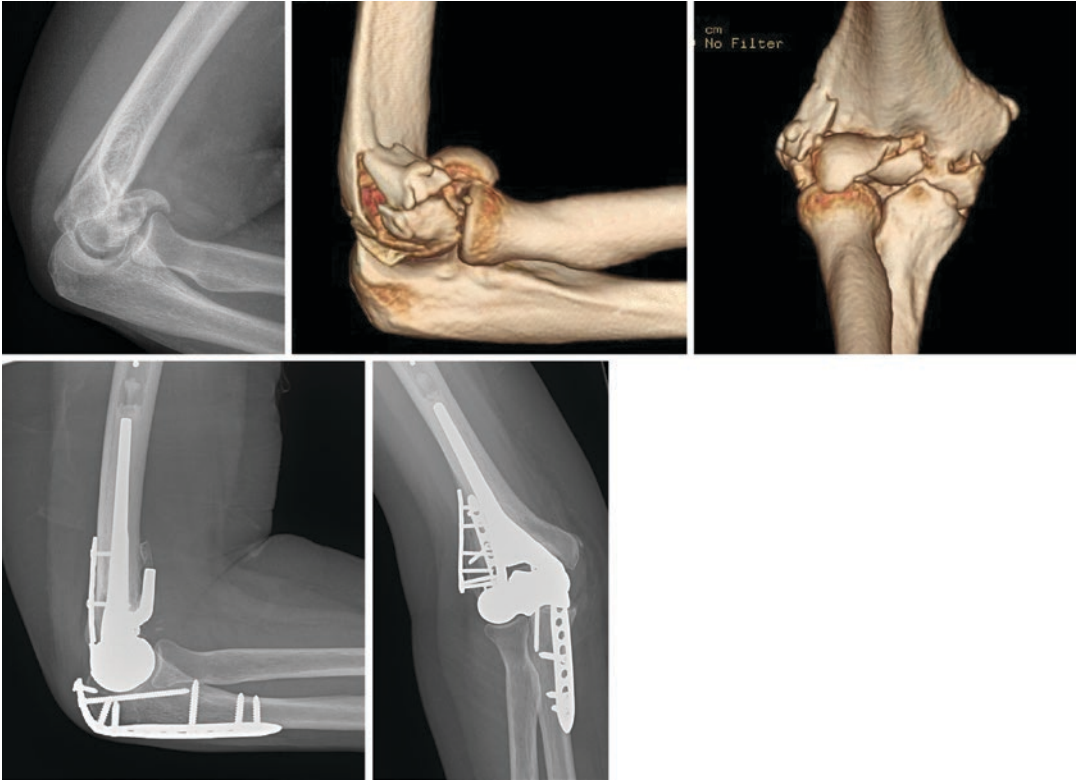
Radiographs and three-dimensional computed tomography of a 51-year-old female with a low transcondylar distal humerus fracture treated with an elbow hemiarthroplasty and open reduction and internal fixation of the lateral column. Exposure was obtained using an olecranon osteotomy
